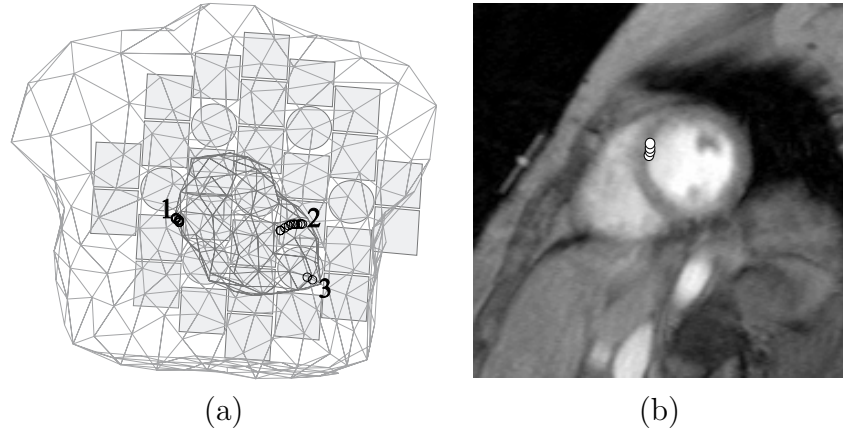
(a) Frontal view of the boundary element torso model of a patient. The outer thorax boundary is represented by 672 triangles, while the pericardial surface was divided into 182 triangles. Open circles refer to the MCG localization results in sinus rhythm: (1) during initial 20 ms of atrial activation, (2) during initial 20 ms of ventricular depolarization, and (3) during pacing at the stimulus peak and during the reponse 3 ms later. Outlines of measurement sensors are also depicted. (b) MCG localization results of a patient overlaid on short-axis MR images of the heart: Spontaneous ventricular depolarization during initial 10 ms of the QRS complex (2 ms step). (Source: Publication V)
